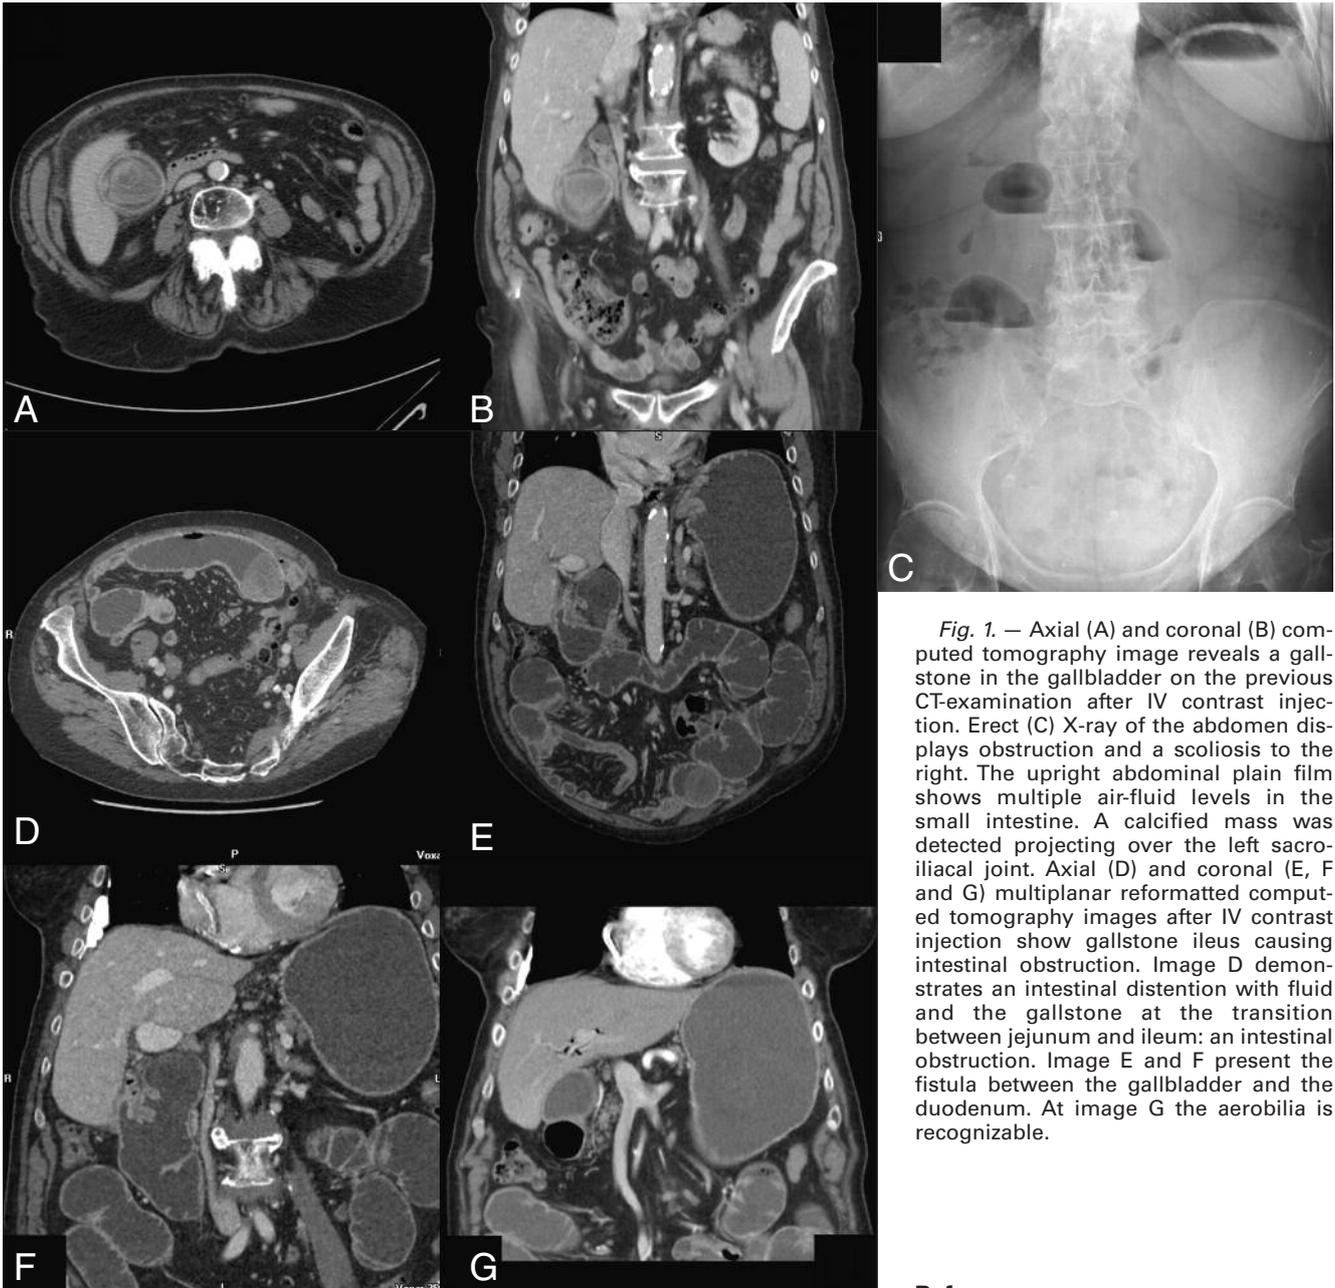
Axial (A) and coronal (B) computed tomography image reveals a gallstone in the gallbladder on the previous CT-examination after IV contrast injection. Erect (C) X-ray of the abdomen displays obstruction and a scoliosis to the right. The upright abdominal plain film shows multiple air-fluid levels in the small intestine. A calcified mass was detected projecting over the left sacroiliac joint. Axial (D) and coronal (E, F and G) multiplanar reformatted computed tomography images after IV contrast injection show gallstone ileus causing intestinal obstruction. Image D demonstrates an intestinal distention with fluid and the gallstone at the transition between jejunum and ileum: an intestinal obstruction. Image E and F present the fistula between the gallbladder and the duodenum. At image G the aerobilia is recognizable.
